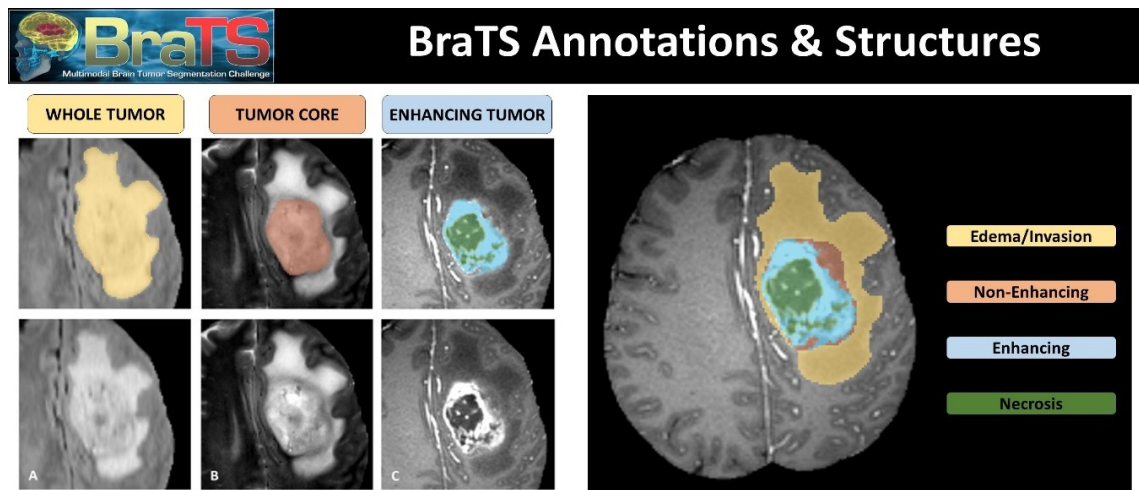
(A) The visibility of WT in FLAIR (B) The visibility of TC in T2 (C) The visibility of structure of enhancing tumor as blue in T1C, nearby the cystic/necrotic components of the core as green (D) Segmentations are joint to create the final labels of the tumor [23]
